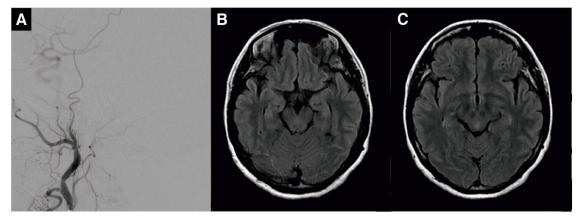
(A) Lateral view of left ECA angiogram showing no DAVF after embolization. (B and C) Images obtained with MRI–FLAIR showing no abnormal signals after embolization. DAVF: dural arteriovenous fistula; ECA: external carotid artery
